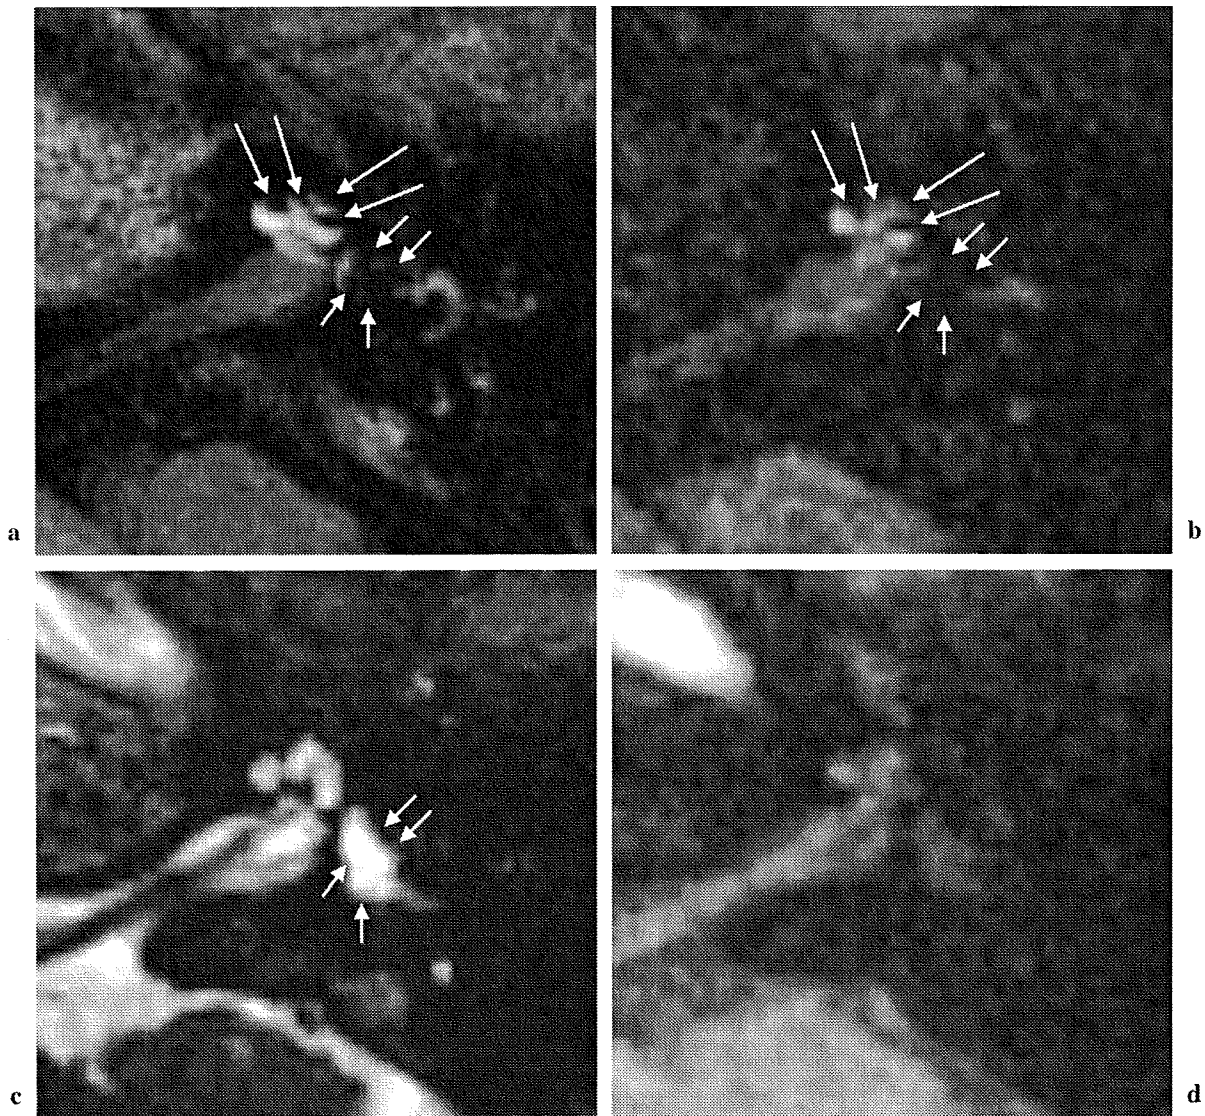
A 46-year-old man with Ménière's disease. On both 3-dimensional fluid-attenuated inversion recovery using conventional turbo-spin-echo (3D-FLAIR-CONV) (a) and using variable flip-angle technique (3D-FLAIR-VFL) (b), the size of the endolymphatic space in the cochlea (arrows) and vestibule (short arrows) were scored as 3, although endolymphatic space in the cochlea is more clearly depicted on 3D-FLAIR-CONV. Almost no Gd-DPTA is seen in the vestibule in this case, whereas the vestibule is filled with lymphatic fluid on 3D-constructive interference in the steady state (CISS) (short arrows, c). On T₁-weighted 3D-fast low-angle shot (FLASH) (d), signal enhancement of perilymphatic fluid is quite faint; thus the discrimination between perilymph and endolymph is impossible.
